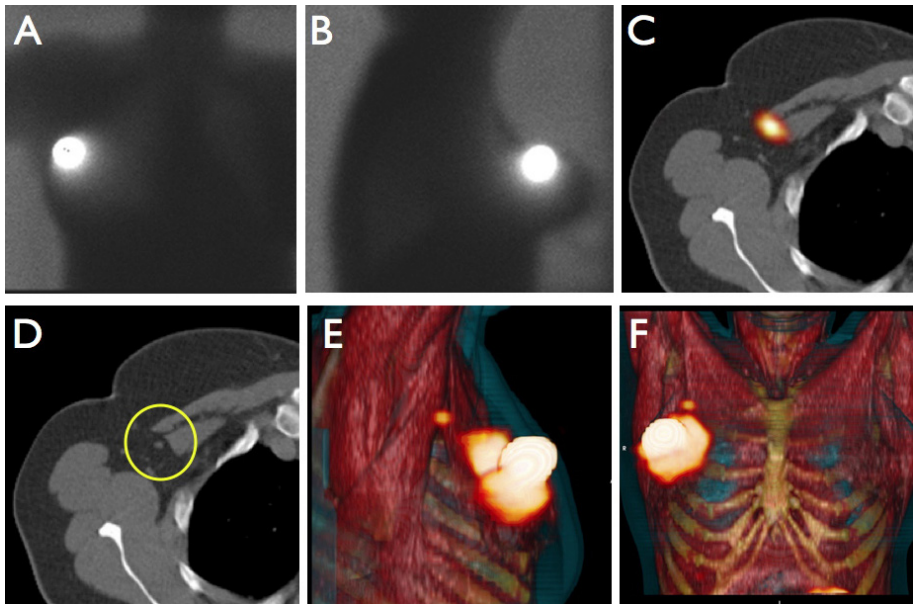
Anterior (A) and lateral (B) planar images showing no drainage of the radiocolloid from the injection site. By contrast, on axial fused SPECT/CT image (C) showing an SLN, corresponding to a single LN on a CT image (circle in D), is seen at the border of the pectoral muscle. This SLN is displayed using 3-D volume rendering for better anatomical recognition (E, F).
